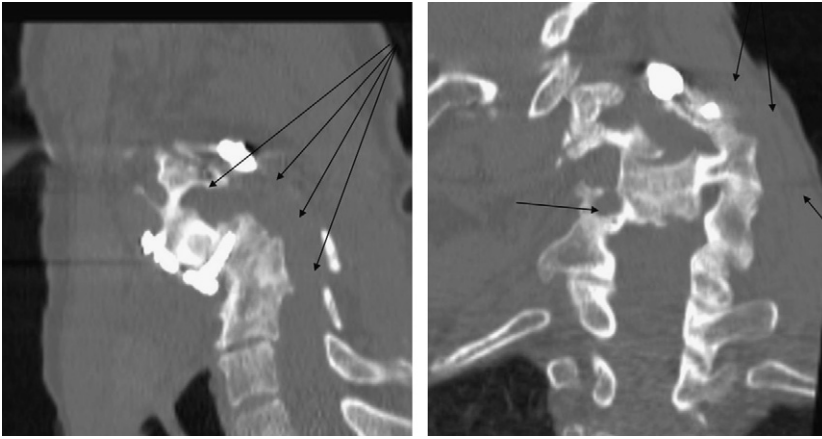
(Left) Sagittal computed tomography (CT) image showing severe cervical sagittal malalignment (arrows). (Right) Anterior-posterior CT image showing severe coronal malalignment (arrows).
